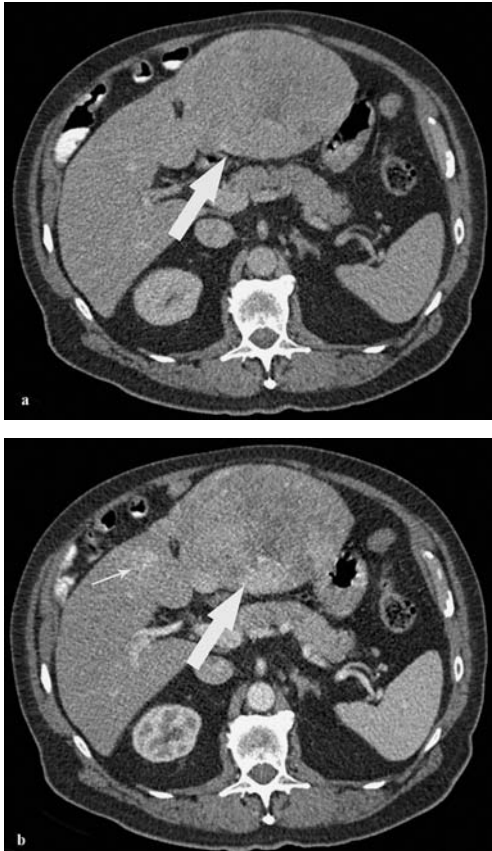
Two HCC nodules in a 58-year-old cirrhotic man. Dynamic-enhanced CT. (a) Axial unenhanced CT image demonstrates a well delineated inhomogeneous nodule in the left lobe (arrow). (b) On an arterial-enhanced CT image the nodule evidences an inhomogeneous enhancement (arrow). Another adjacent hypervascularized nodule is detected (small arrow).
